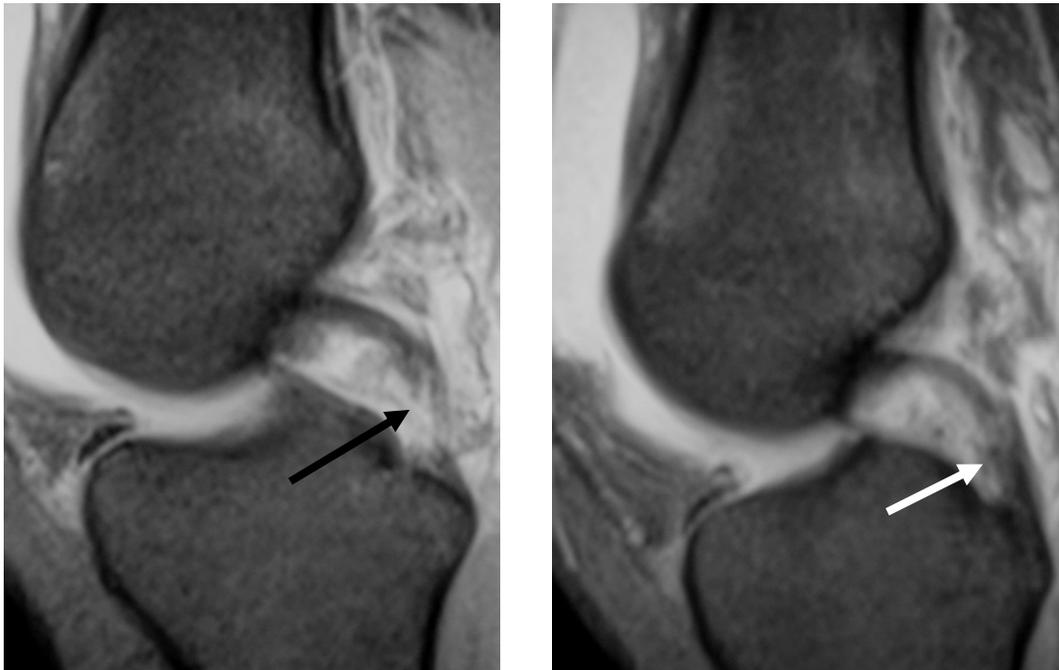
a-b. Sagittal T2-weighted images taken 2 years apart shows a high grade partial tear of the PCL (black arrow in a) that is shown to be healed 2 years later (white arrow in b).
